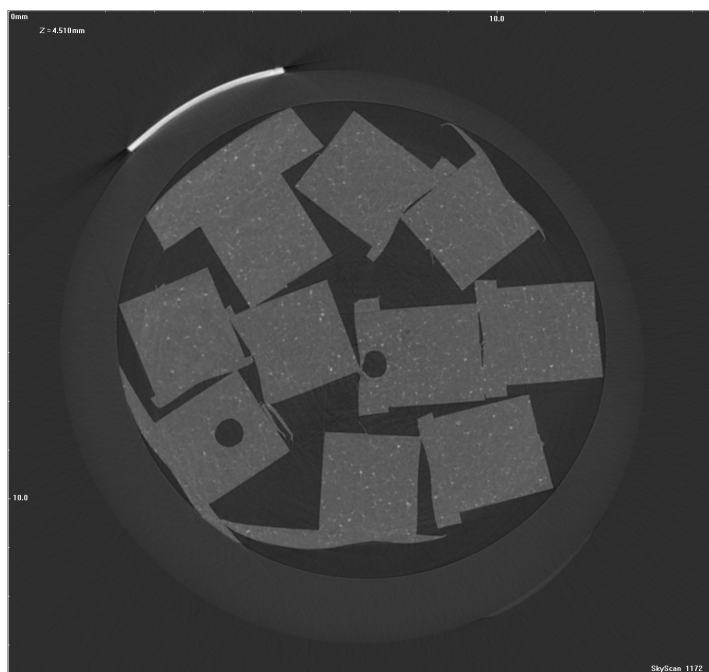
A slice of the stack where stability test samples have been imaged with Skyscan μ CT. No notable difference can be seen between the samples. The rounding light grey circle is a plastic vessel in which the samples were packed. The bright narrow line is a piece of plastic tape for identification purposes.
